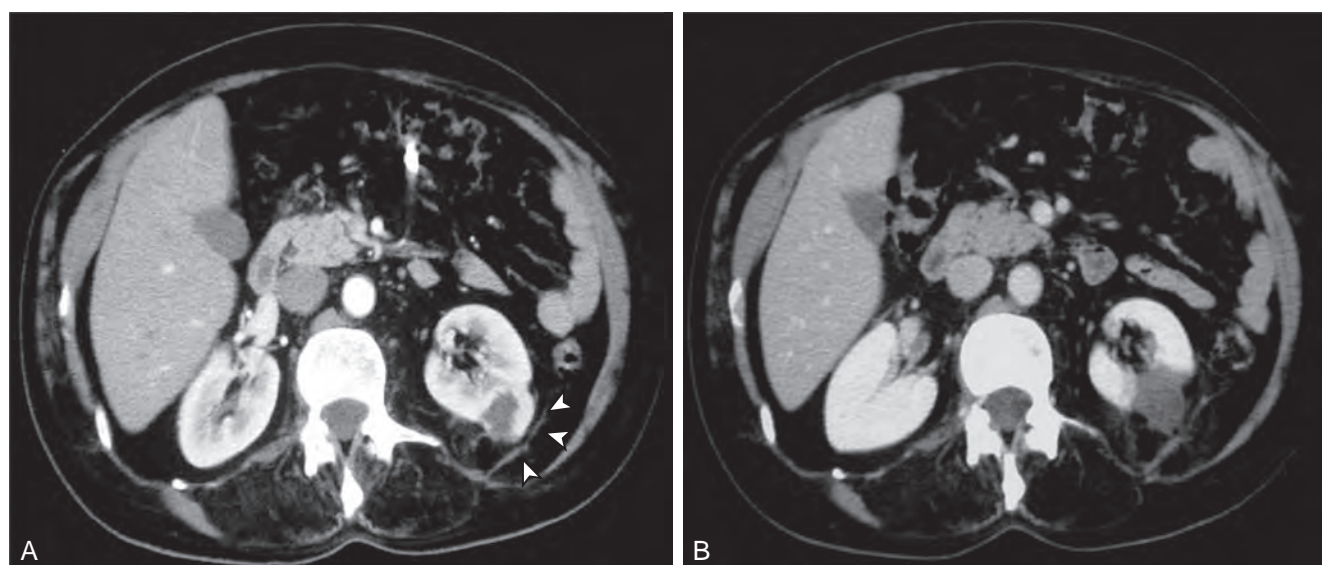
Incomplete ablation with radiofrequency ablation. A, Six-week follow-up computed tomography scan shows contrast enhancement of a left renal cell carcinoma indicative of an incomplete ablation (arrowheads). B, After repeat ablation, the tumor shows no further enhancement on subsequent 6-week follow-up.
